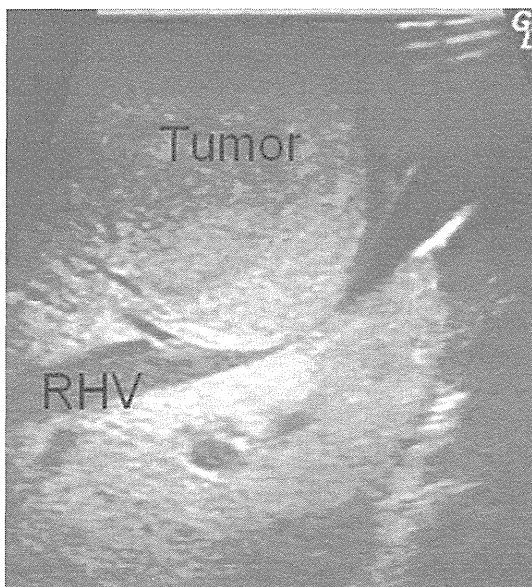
Ultrasonography of the patients who underwent total hepatic resection of the right hepatic vein drainage area (THR-RHV). The right hepatic vein (RHV) was compressed by hepatocellular carcinoma
